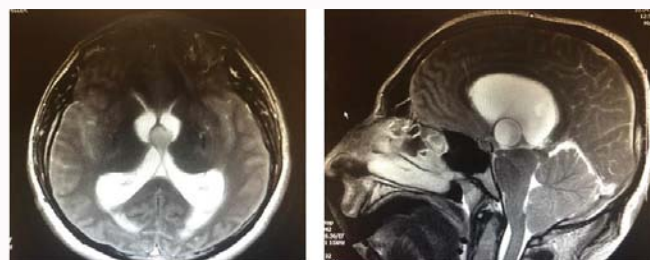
Colloid cyst with a uniformly defined mass image in the midline and hydrocephalus at Cranial MRI.
